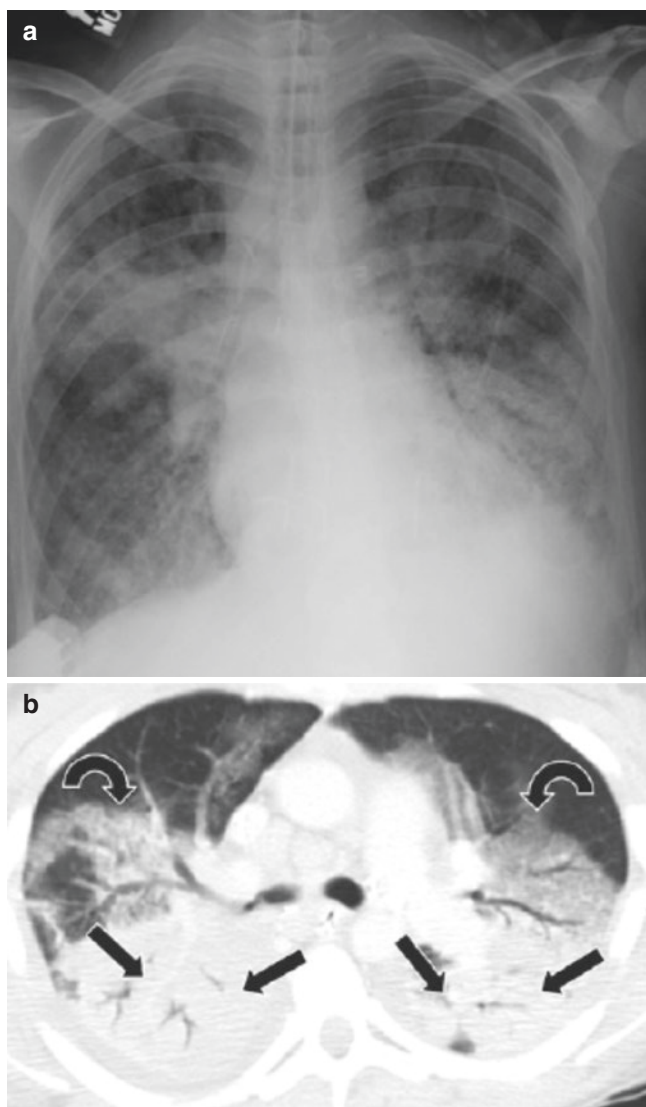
A 17-year-old girl with bilateral lung transplantation for cystic fibrosis who presents with fever and elevated white blood cell counts. *Staphylococcus aureus* pneumonia was confirmed on bronchoalveolar lavage. (a) Chest radiograph shows multifocal air-space consolidations in both lungs. (b) Axial lung window CT image demonstrates ground-glass opacifications (curved arrows) and air-space consolidations (straight arrows) in both lungs. Also noted are several air bronchograms within the consolidated portions of lungs
